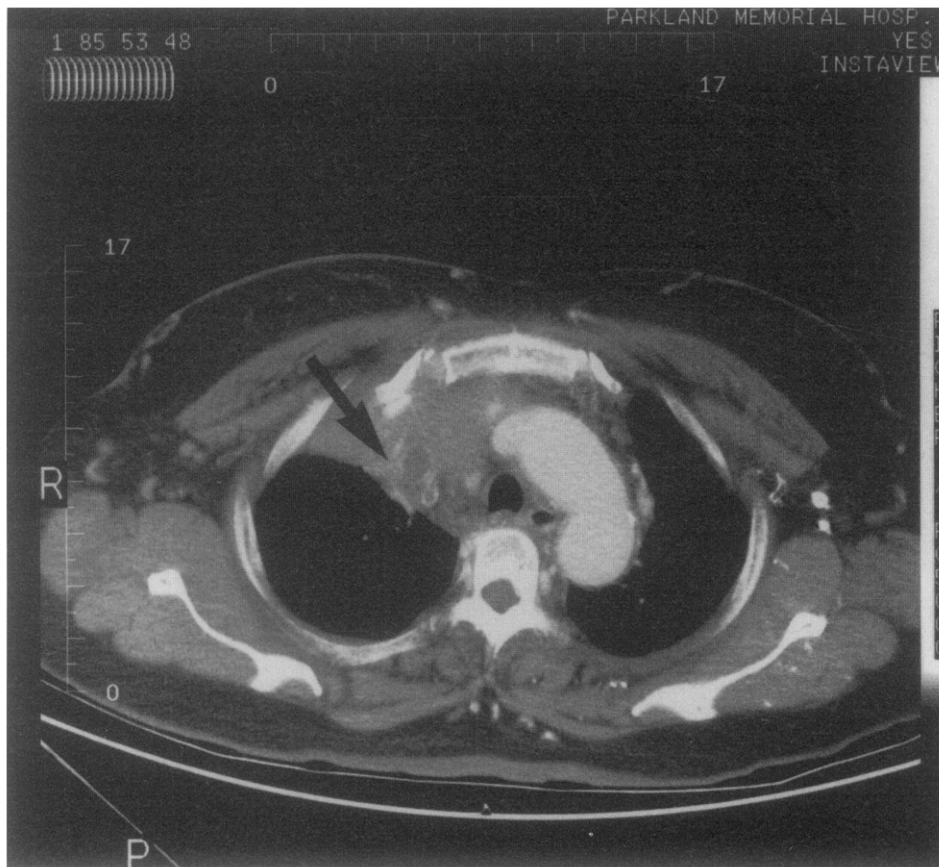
Chest CT scan demonstrates tumor mass encasing a thrombosed SVC (arrow).
